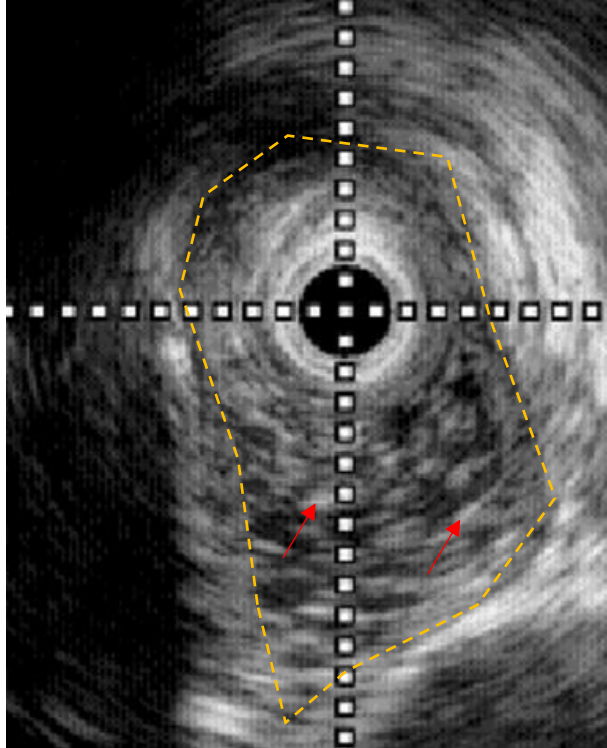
Example Ultrasound Image taken during a HRIM study. This is an ultrasound image from a HRIM swallow study. The shape of the saline bolus is outlined with a yellow dashed line. Outside of that margin is the esophageal tissue. The bolus of saline is dark gray, speckled with white dots from air bubbles. Red arrows point out a couple of the air bubbles. There are air bubbles in the saline solutions during swallow which are evident with ultrasound imaging. Unpublished figure.
